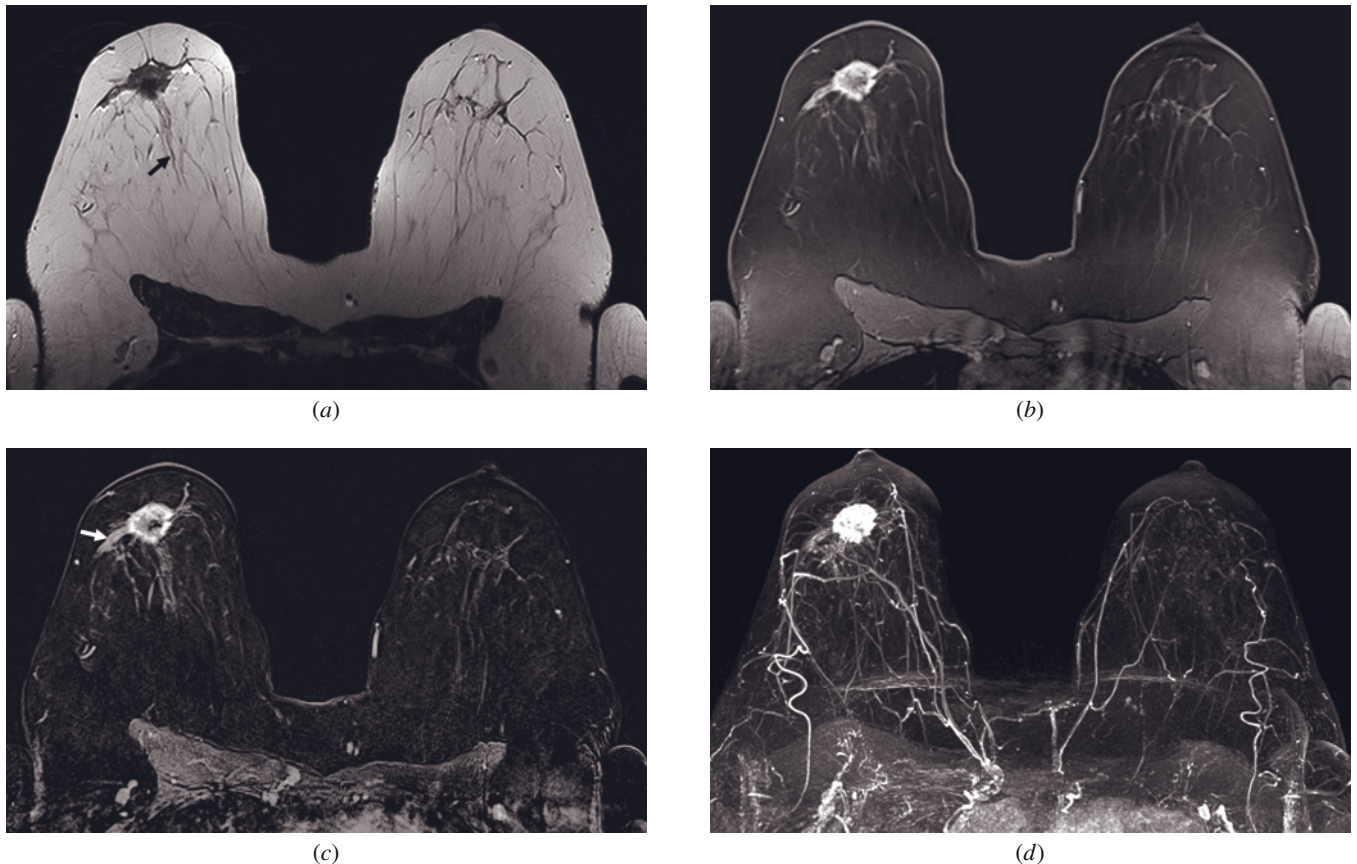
Invasive ductal carcinoma (IDC). Axial T2-weighted image (a) shows an irregular, heterogeneous, hypointense mass with spiculated margins and a “hook sign” (black arrow) in the subareolar region of the right breast. On postcontrast GRE (b) and subtracted (c) images, two parallel areas of non-masslike enhancement in ductal distribution extending from the cancer (white arrow, c) depict the morphologic pattern suggestive of DCIS. MIP image (d) shows a more prominent vascularity of the right breast compared to the left.
